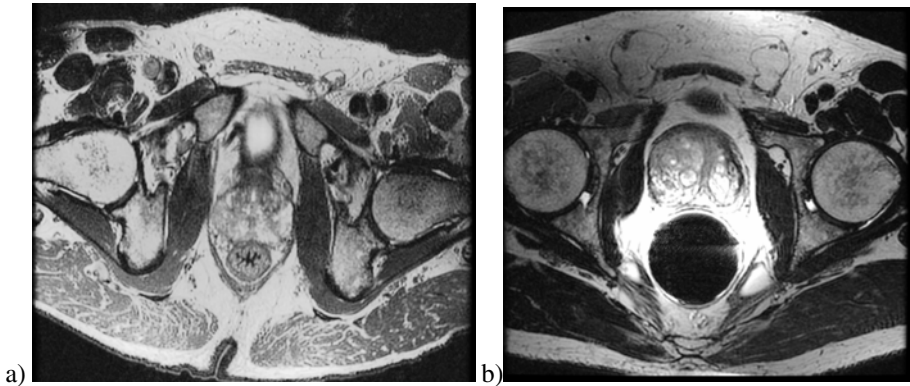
Example MRI scans - conventional (a) and with an endoanal coil (b)
